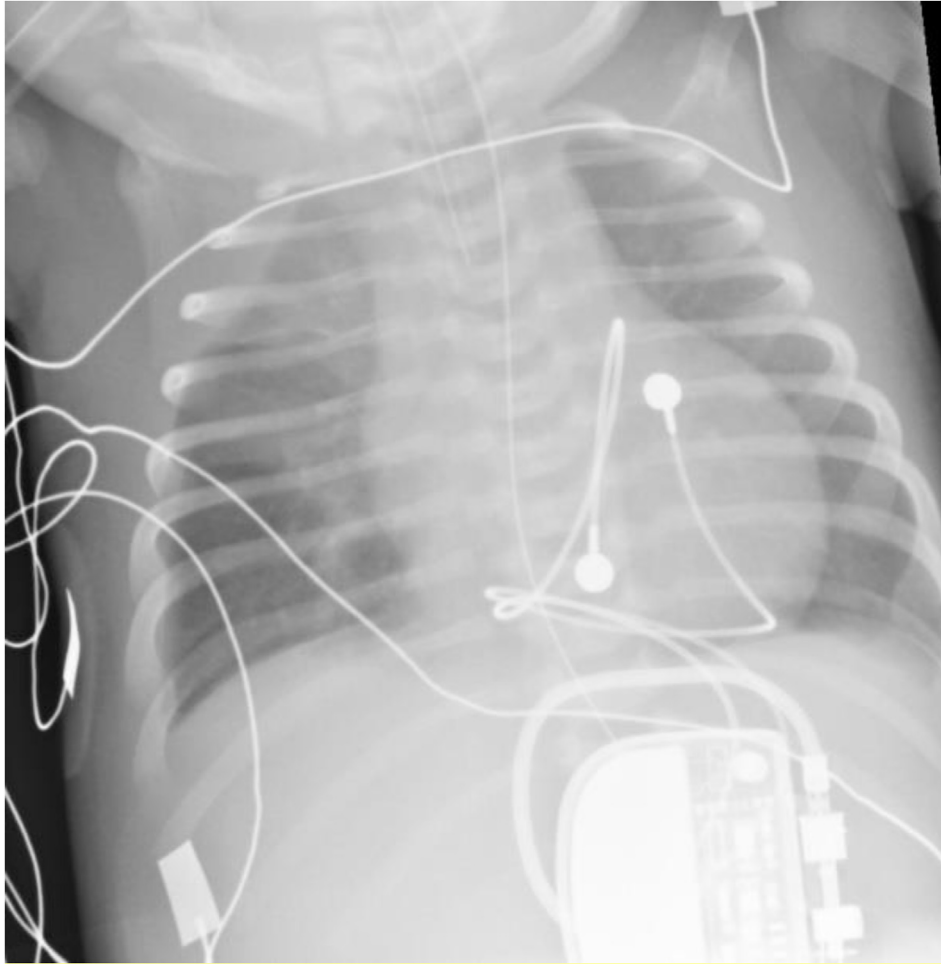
Post-operative Chest Radiograph on day 1 of life.
